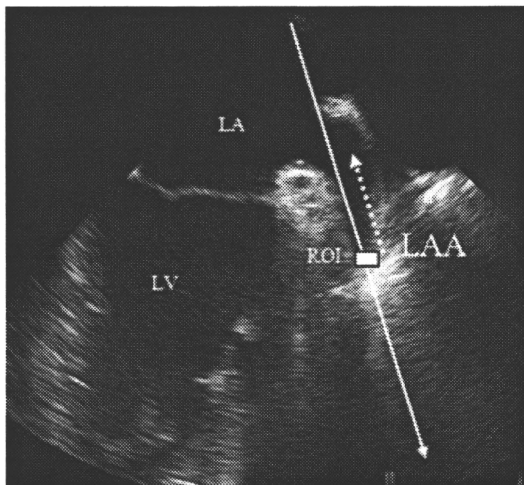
Measurement of left atrial appendage wall velocity (LAAWV) using pulsed tissue Doppler with transesophageal (TEE) (left panel) and transthoracic (TTE) (right panel) echocardiography. The sample volume (white arrows) for the measurement of LAAWV is placed at the tip of the LAA. The peak wave during the LAA contraction phase is designated as LAAWVc, and the peak wave during the LAA relaxation phase is designated as LAAWVr. ROI = region of interest.
